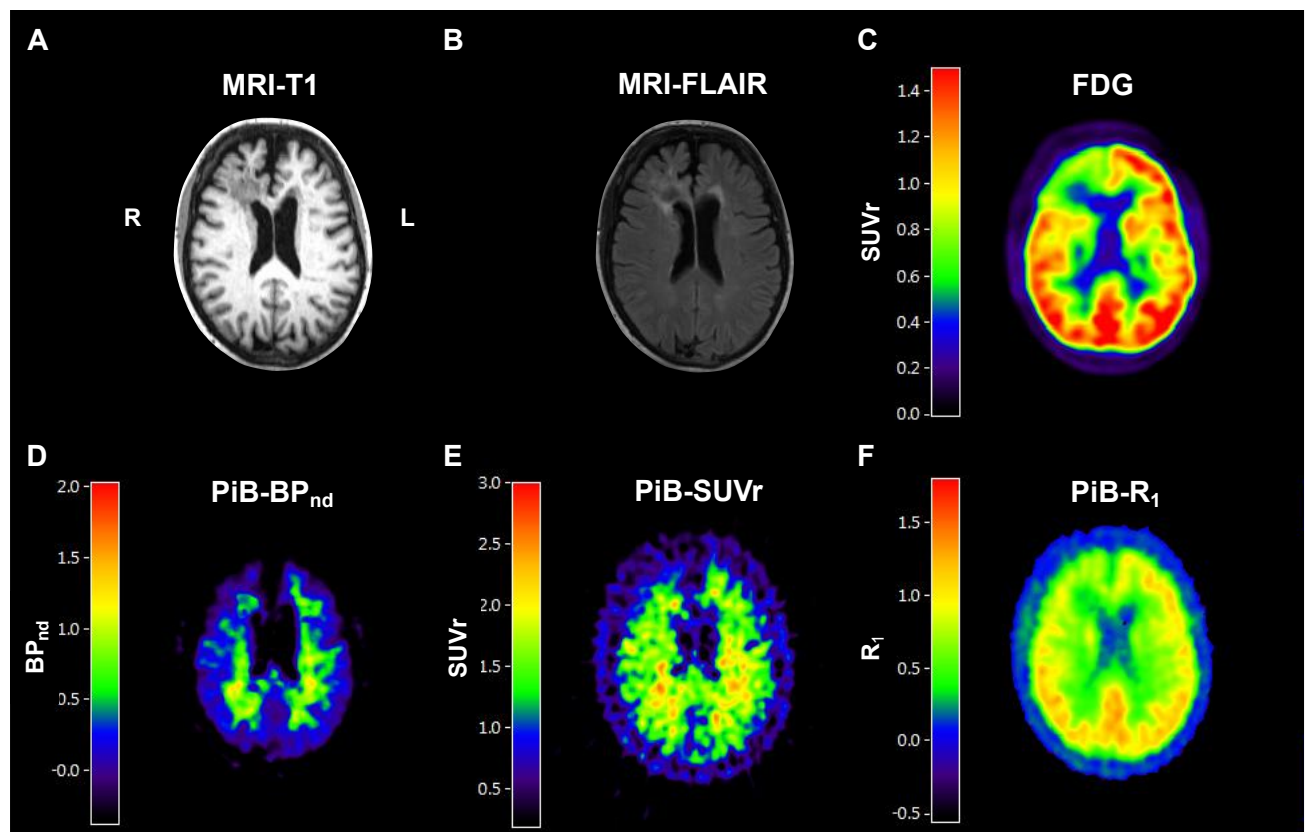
Axial T1, FLAIR, [¹⁸F]FDG-SUVr and [¹¹C]PiB BP_{nd}, SUVr and R₁ PET
